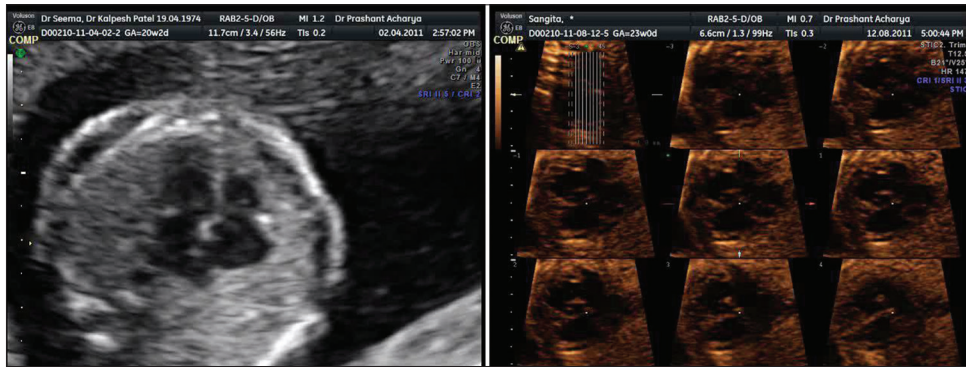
Fetal heart in two-dimensional and three-dimensional CT slice mode
